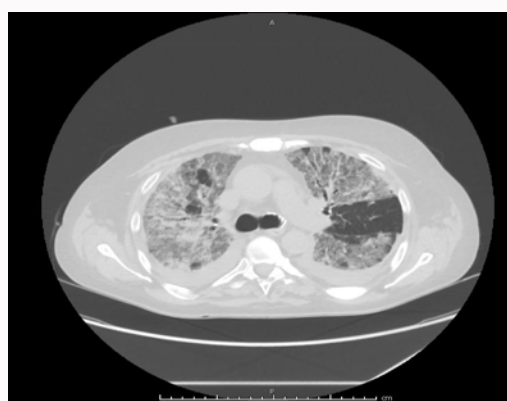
Case 3: Diffuse bilateral pulmonary infiltrates found on urgent chest CT scan in patients with severe respiratory symptoms.
